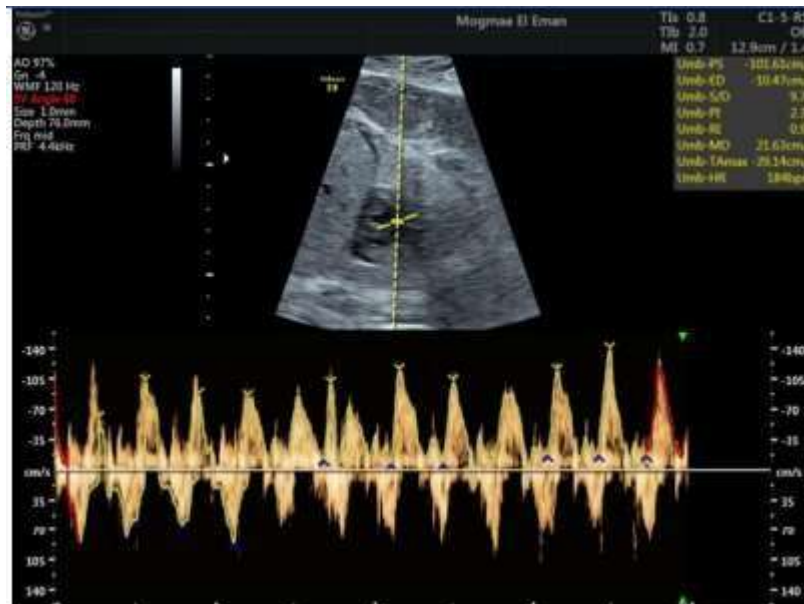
fetal pulmonary artery Doppler (Alkashty, et al. 2021).
